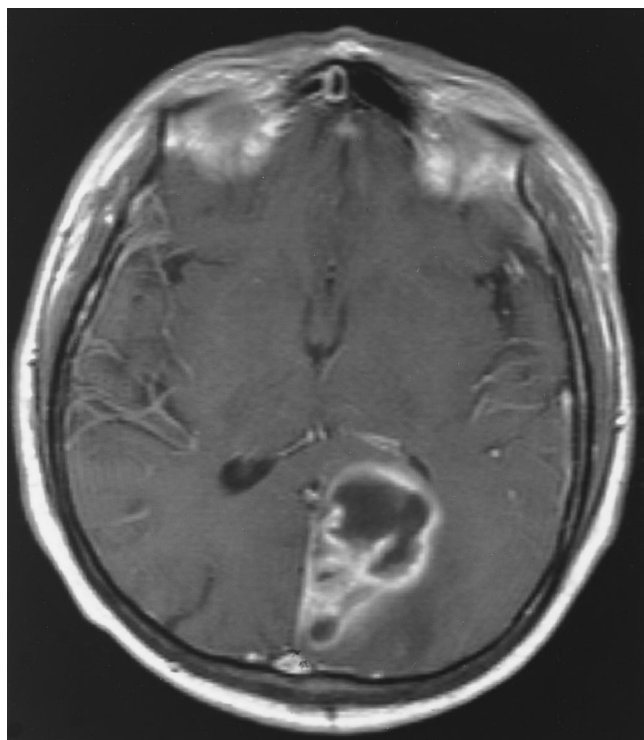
T1-weighted MRI scan of the brain of the patient in figure 1, obtained after administration of an intravenous gadolinium contrast agent; a thin-walled, irregular, septated capsule (with contrast enhancement) with central hypointensity is evident.
